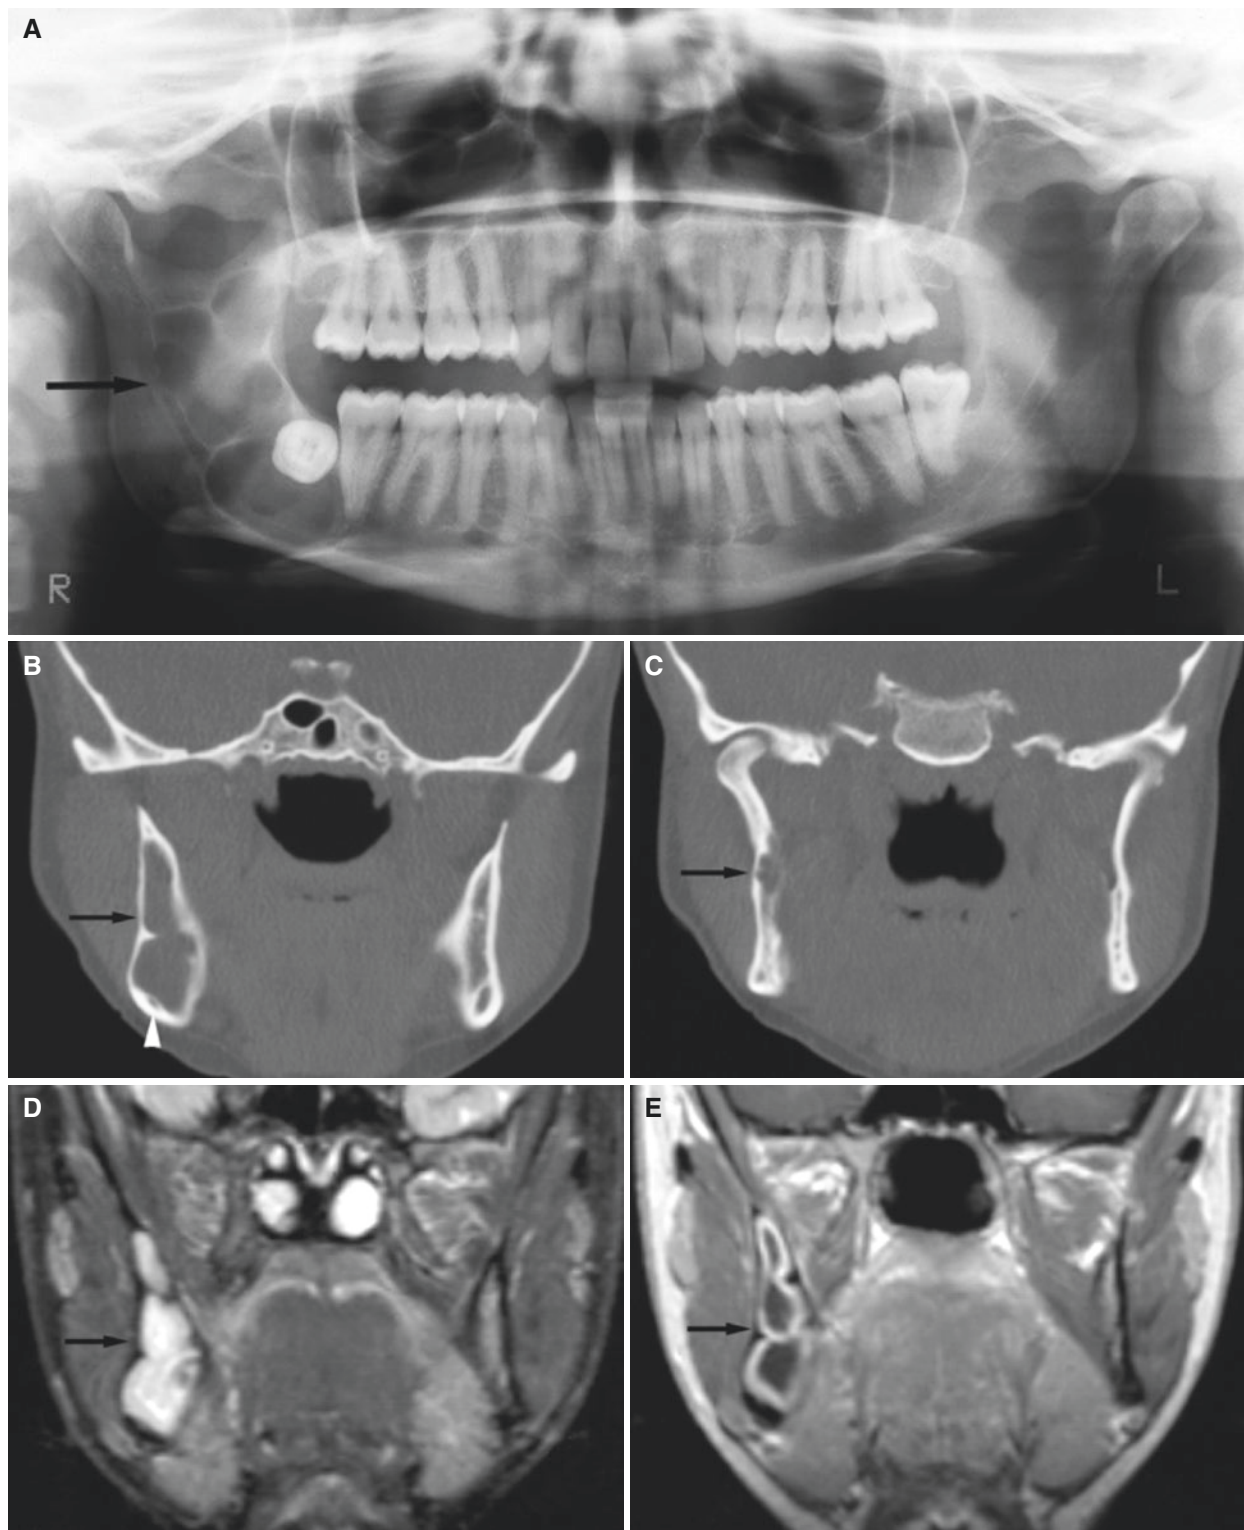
Keratocystic odontogenic tumor, mandible; 42-year-old female with incidental finding at routine dental radiography. (A) Panoramic view shows scalloped radiolucency with bone septa and impacted third molar (*arrow*). (B) Coronal CT image shows expansive radiolucency with intact cortical bone (*arrow*), and mandibular canal displaced peripherally (*arrowhead*). (C) Coronal CT image shows
